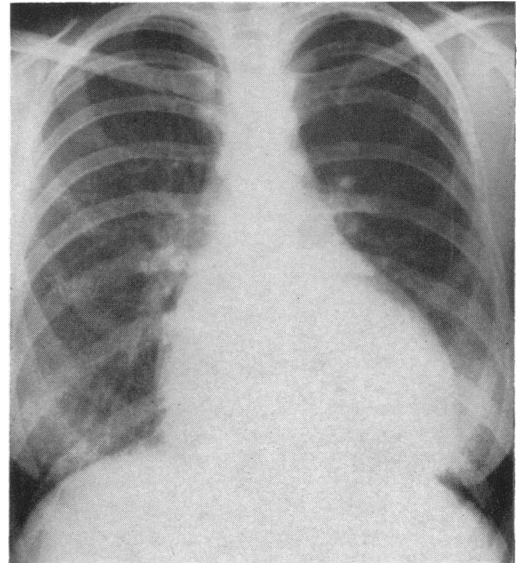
Six-foot plain radiograph of chest of Case 7, showing globular heart with enlargement of both ventricles and right atrium.
